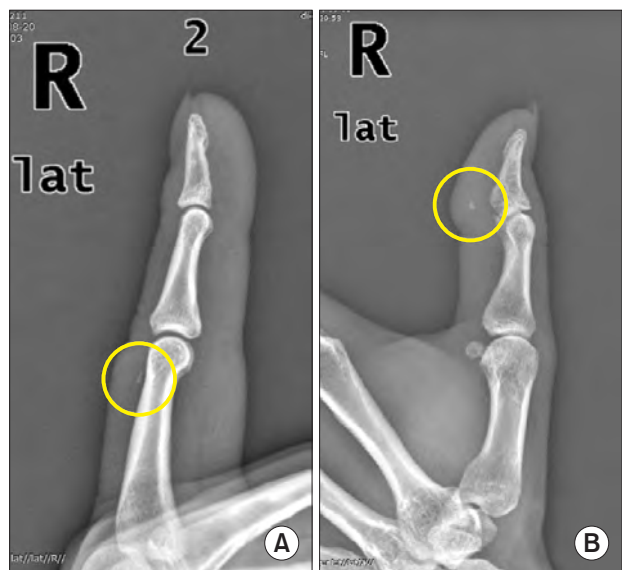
Preoperative X-ray findings. (A) Foreign body of right second finger. (B) Foreign body of right thumb.
